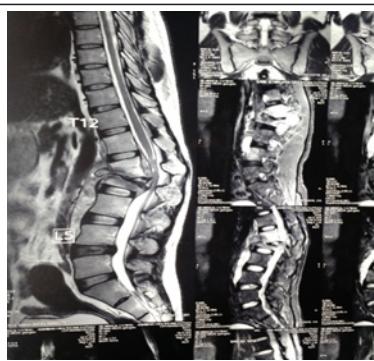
Preoperative MRI of D1 spine with screening of whole spine
